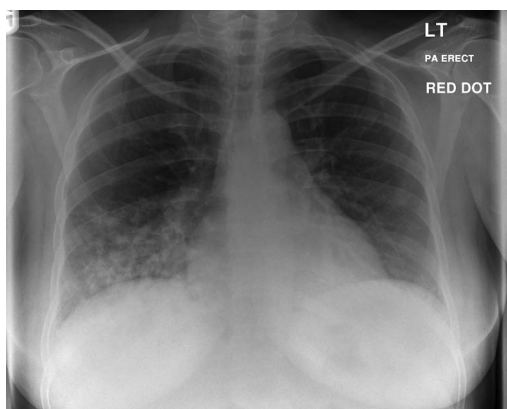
Chest radiograph showing right lower lobe consolidation.
